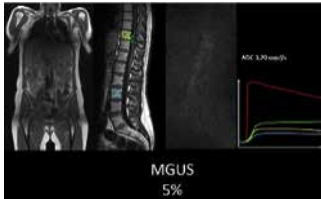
WB-MRI, DCE-MRI (+TIC) and DWI in MGUS with 5% plasma cells
